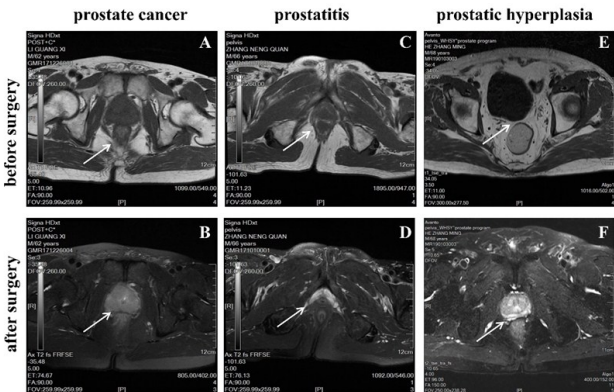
Representative MRI images of a (A-B) prostate cancer patient, (C-D) prostatitis patient and (E-F) prostate hyperplasia patient before and after surgery.
